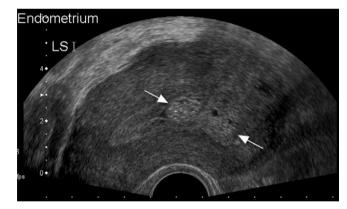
Transvaginal ultrasound demonstrating endometrial thickening (white arrows) secondary to a polyp.
